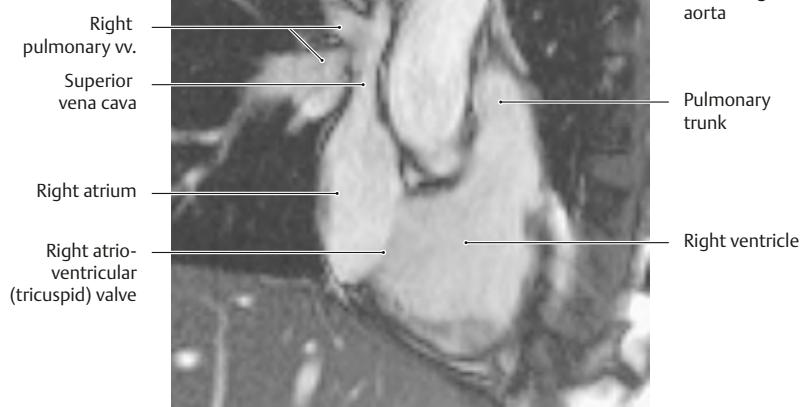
MRI of the heart
